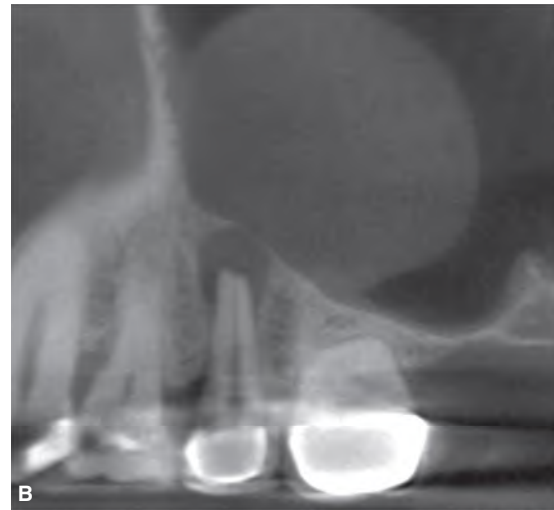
Periapical mucositis. A. Periapical radiograph of a failing root canal treatment of the maxillary left second premolar. The distal extent of a periapical mucositis lesion is evident (arrow). B. Sagittal CBCT image of the periapical mucositis lesion emanating from the apex of the maxillary left second premolar. Mucositis may be indistinguishable, radiographically, from sinogenic mucoceles and mucous retention cysts, and requires an accurate endodontic diagnosis to confirm.
